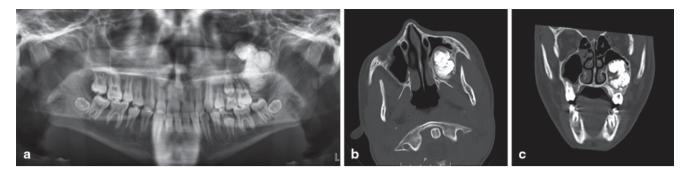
Panoramic radiograph and computed tomography (CT) scan showing large mixed radiolucent/radiopaque lesion in left posterior maxilla (a, b, c). The lesion contains material of tooth density with a thin soft tissue rim
